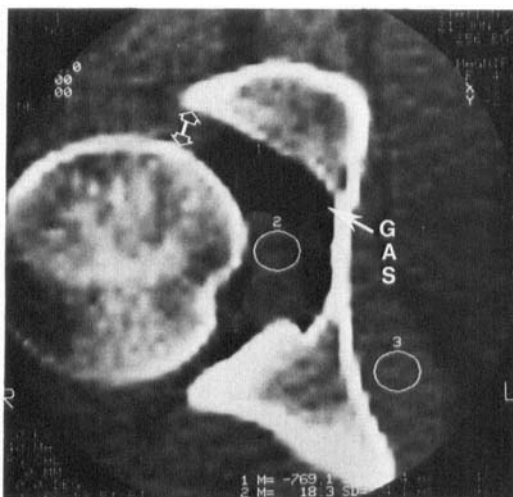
Central CT-image showing subluxation and a vacuum phenomenon. Note the increased anterior joint space.
